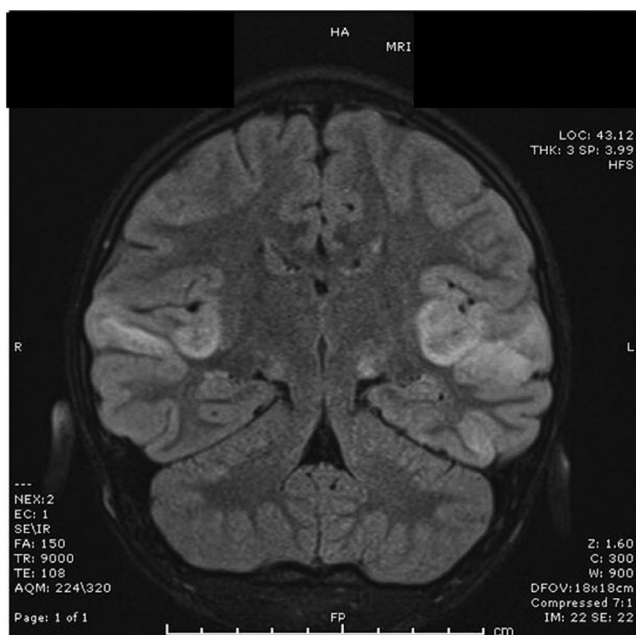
Coronal View of MRI: MRI reveals bilateral diffusion restriction and edema associated most extensively within bilateral temporal lobes, frontal and temporal cortices along the Sylvian fissures, the left inferior temporal lobe, and bilateral thalami. Perfusion sequences demonstrate hyperemia in the temporal lobes and Sylvian fissures. These findings are most consistent with herpes encephalitis with subsequent hemorrhagic conversion
